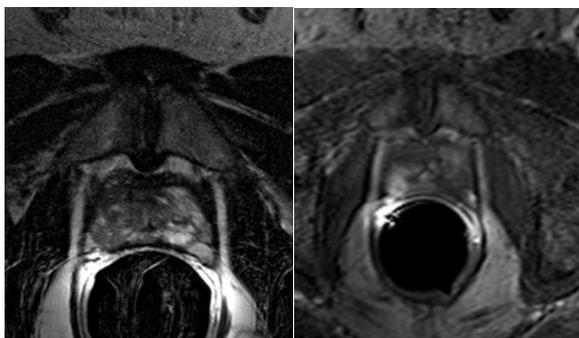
Prostate carcinoma in the right apex; hypointense in the T2W image and early enhancement in DCE-MRI.
